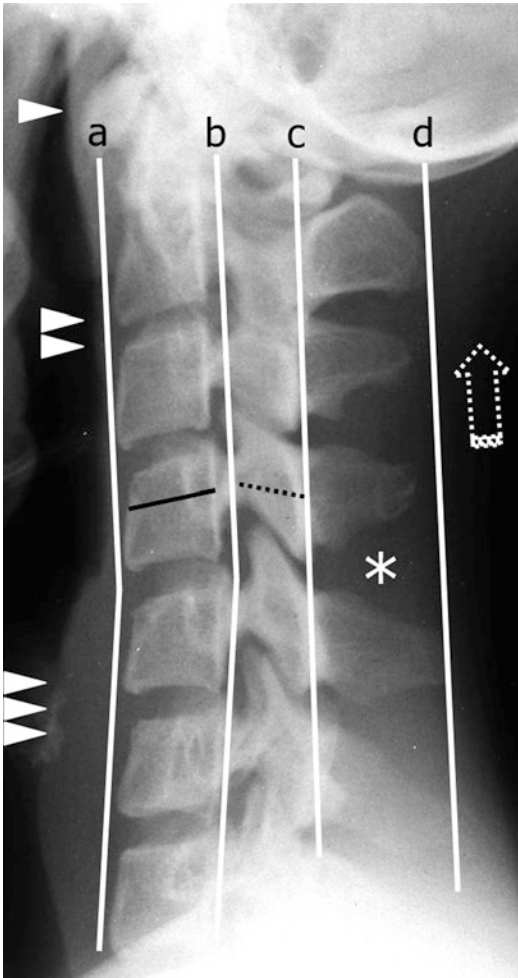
Cervical spine ligamentous injury by anterior flexion distraction injury mechanism: potential of radiography. Lateral view of the cervical spine shows anteriorly concave with fulcrum at C4-C5 level anterior vertebral or marginal (a) and posterior vertebral or marginal (b) lines, straight spinolaminar (c) and posterior spinous (d) lines, as well as the increase of the C4-C5 interarticular and interpinous (asterisk) spaces, from anterior flexion distraction injury mechanism (dashed open arrow). The low ratio between anteroposterior diameters of the spinal canal (dashed line) and vertebral body (continuous line), i.e., the Torg-Pavlov ratio, indicating a congenital stenosis of the cervical spinal canal. Intervertebral spaces are normally symmetric. Prevertebral soft tissues, i.e., nasopharyngeal (single arrowhead), retropharyngeal (double arrowhead), and pretracheal (triple arrowhead) spaces, are normal. These findings required prompt CT scan (not shown) for complete evaluation of posttraumatic scenario
